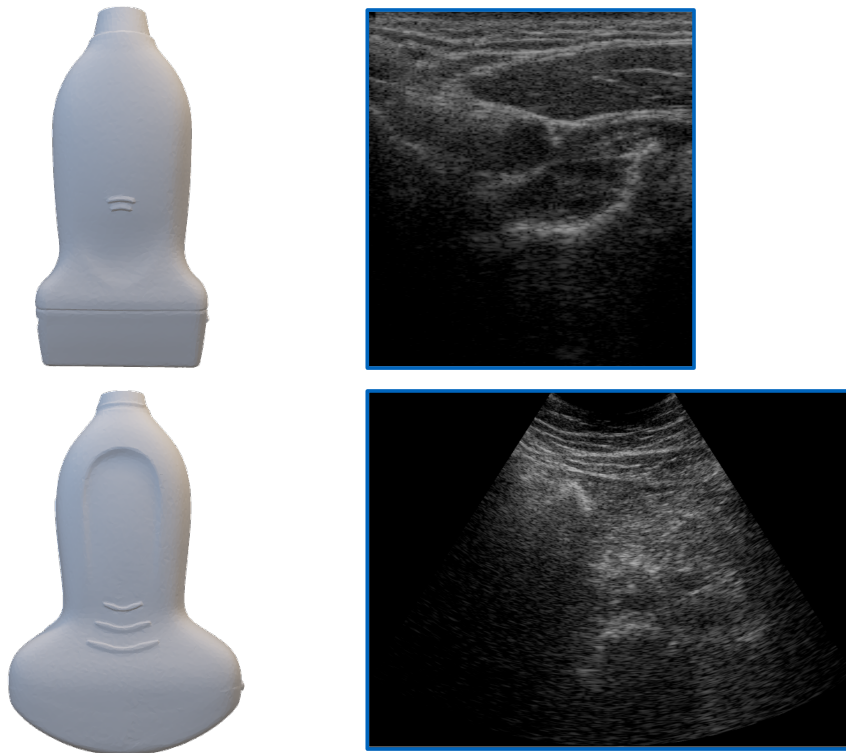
Representation of common ultrasound transducers and examples of ultrasound images obtain using them. Top row: A linear transducer. Bottom row: a curvilinear transducer. Notice how the acquired images reflect the geometry of the probes' piezoelectric elements.
